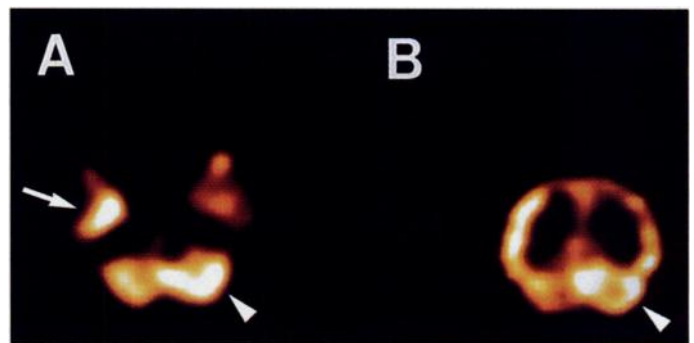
Right temporal epilepsy in a 30-yr-old woman. Ictal brain SPECT images demonstrate typical CCH. Transaxial (A) and coronal (B) images show increased uptake in the right temporal (arrow) and contralateral cerebellum (arrowhead).
